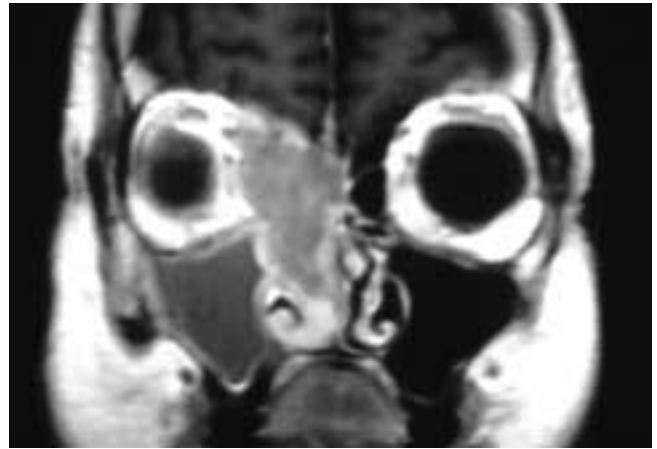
Coronal T1-weighted, contrast-enhanced MR image (on the same patient as in Fig. 6-8) shows an enhancing mass in the right ethmoid complex and nasal fossa. The tumor has broken into the right orbit but has a smooth interface with the orbital fat. The right antrum is obstructed by the mass. This patient had a melanoma.
